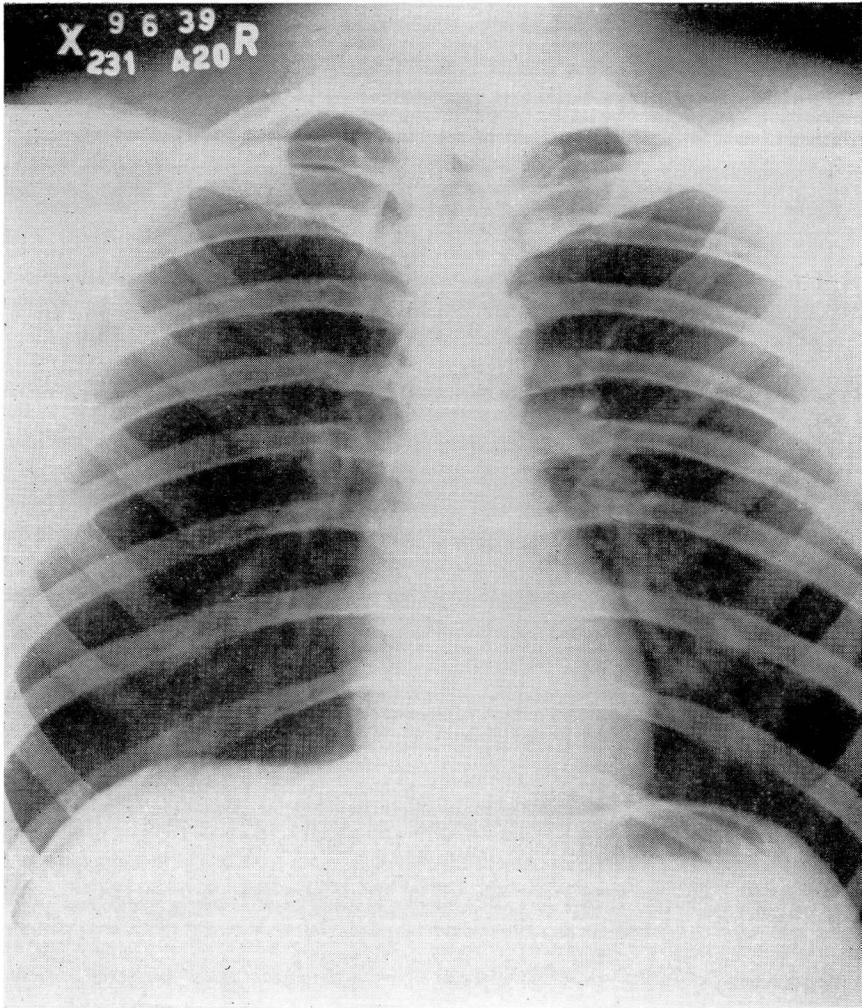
Roentgenogram taken fifteen days later showing complete reexpansion of the right lung and no parenchymal infiltration.
